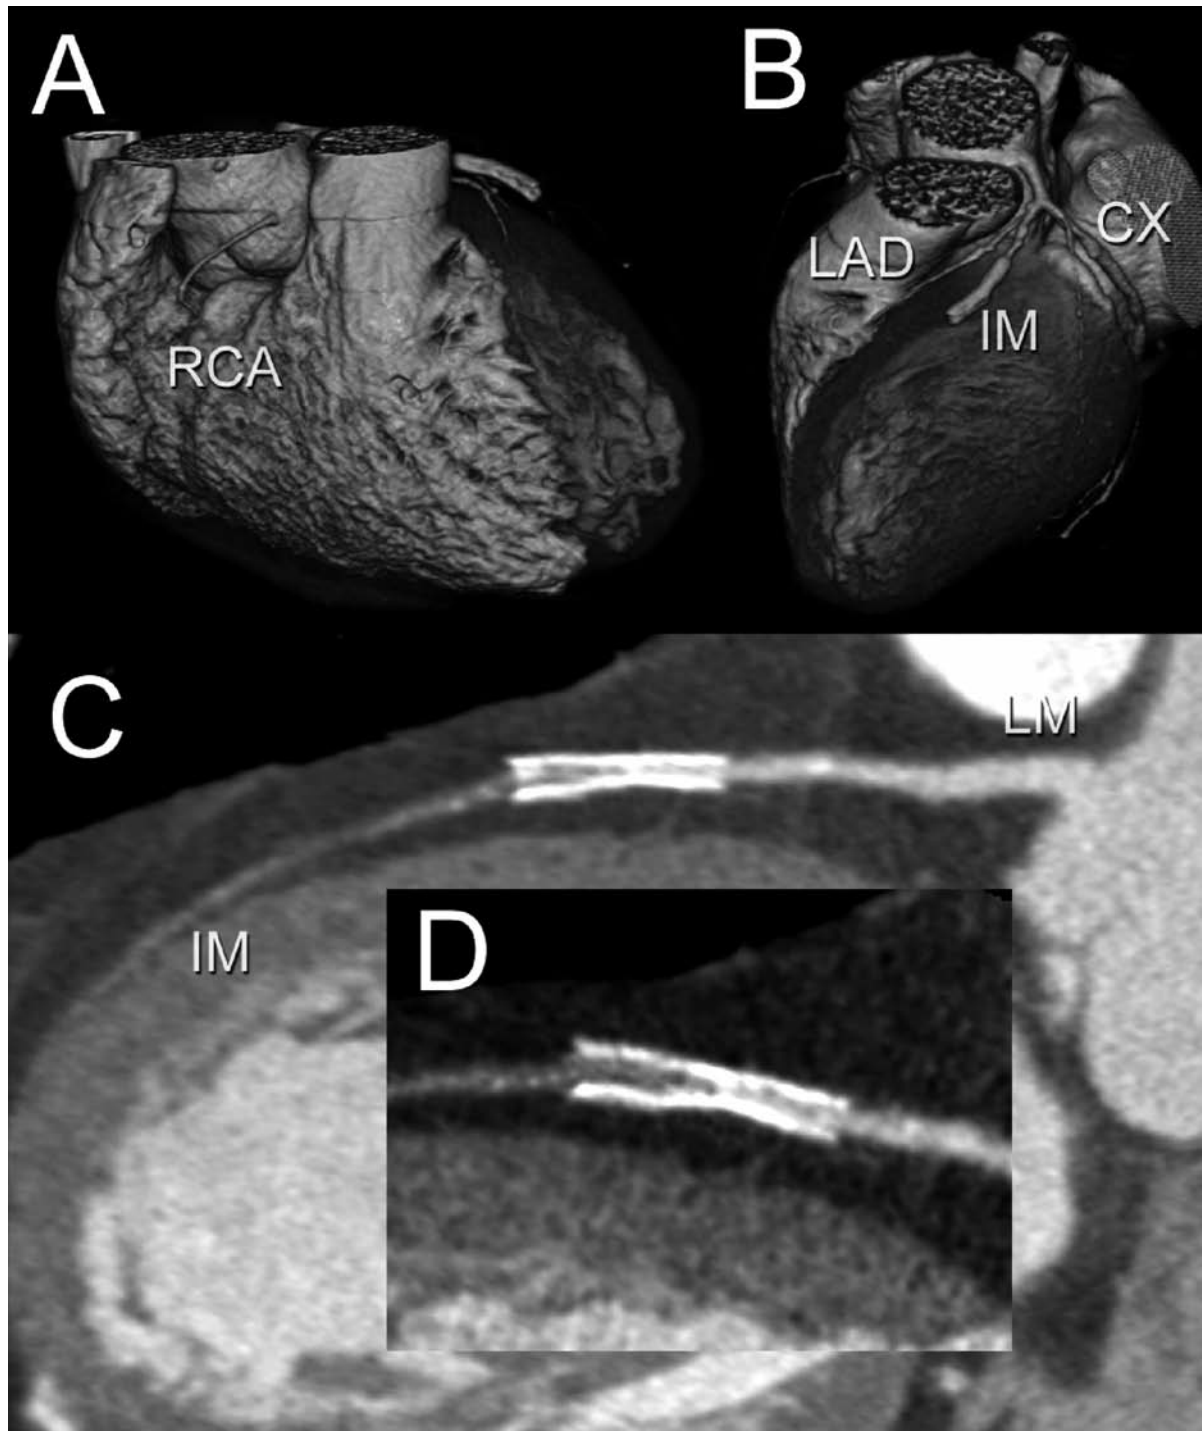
Example of CT-CA in patients with recurrent angina after PCI on the IM. In a patient with left dominance (A) the CT-CA shows a stent in the IM branch (B). The multiplanar reformats along the vessel length (C-D) using standard (C) and high kernel filtering (D), show a hypodense layer in the distal segment of the stent with a resulting stenosis >50% (ISR). The stent appears to be also irregularly expanded.
